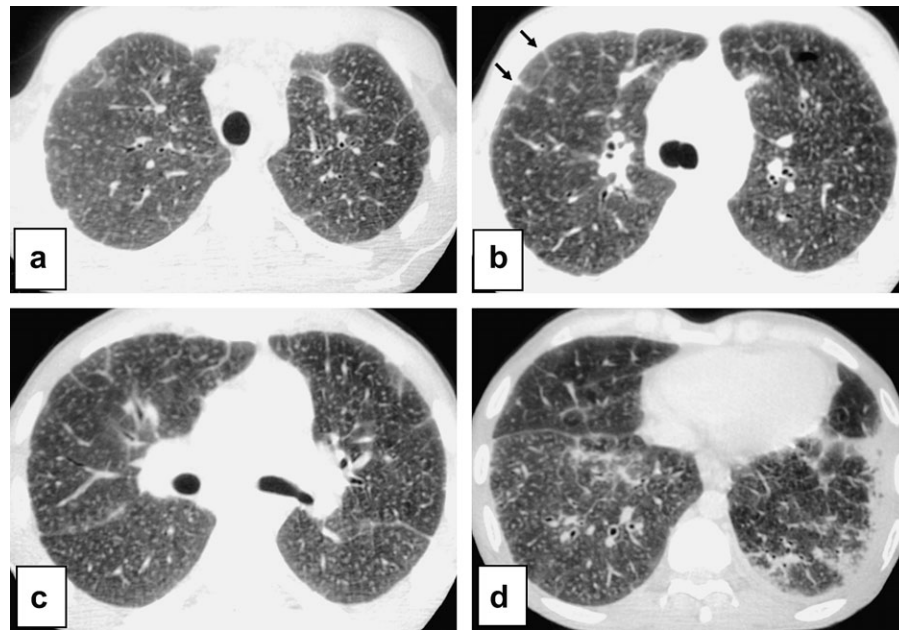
HRCT imaging of Case 8 shows centrilobular nodules throughout entire lungs (a, b, c and d), interlobular septal thickening (b, black arrows) and fibrotic changes in the left lower zone (d).
